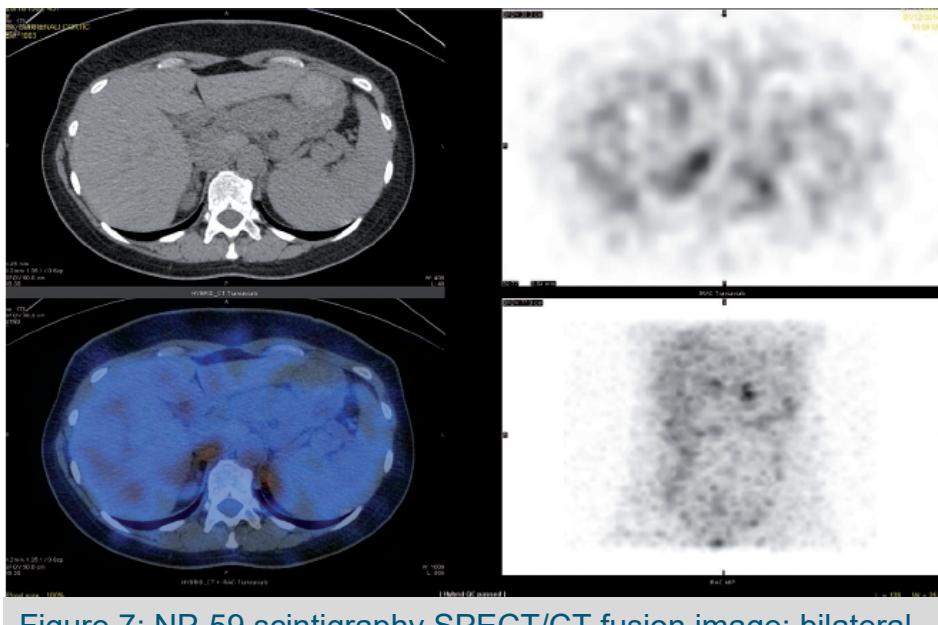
NP-59 scintigraphy SPECT/CT fusion image: bilateral adrenal uptake.
